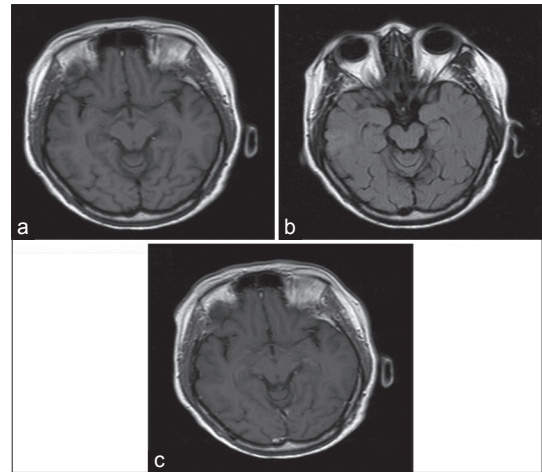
Brain magnetic resonance images (a-c) showing a focus of high signal intensity in left cerebellar peduncle extending to the left side of medulla oblongata on T2 and fluid-attenuated inversion-recovery images showing expansion and peripheral enhancement after contrast injection
